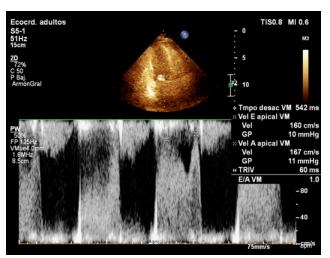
A Doppler echocardiogram of the mitral valve (MV). It shows the auscultatory elements of cardiac cycle changes in critical mitral stenosis
